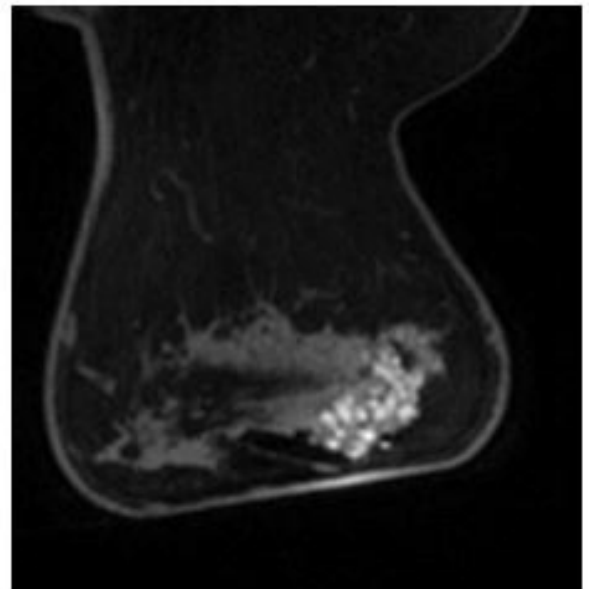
"clumped" area of Gadolinium contrast enhancement on MRI corresponding to the focal asymmetry seen on mammogram. (Biopsy proven invasive ductal carcinoma).
